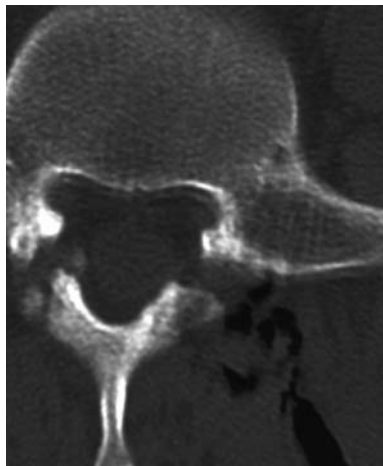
CT image showing distribution of the gas mixture in the lysis points (arrowhead)
